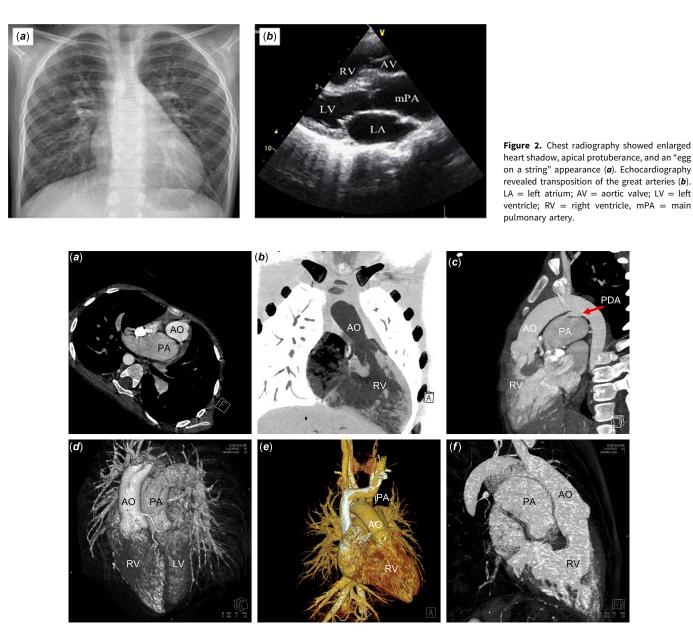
Preoperative cardiac CT confirmed transposition of the great arteries (*a*), with the anatomical relationship of large arteries reversed (*b*-*f*), and PDA (*c*). AO = aorta; PA = pulmonary artery; LV = left ventricle; RV = right ventricle; PDA = patent ductus arteriosus.
